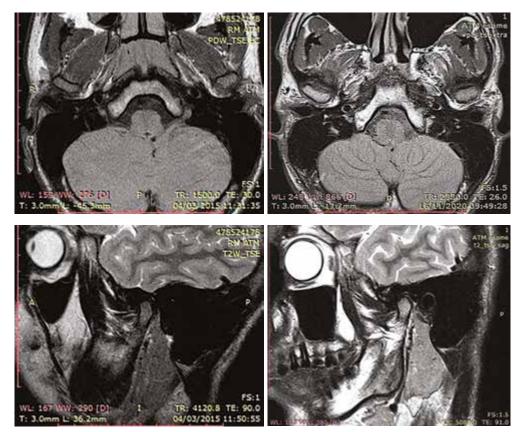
Transversal section MRI. March 2015 (left) and November 2020 (right).
